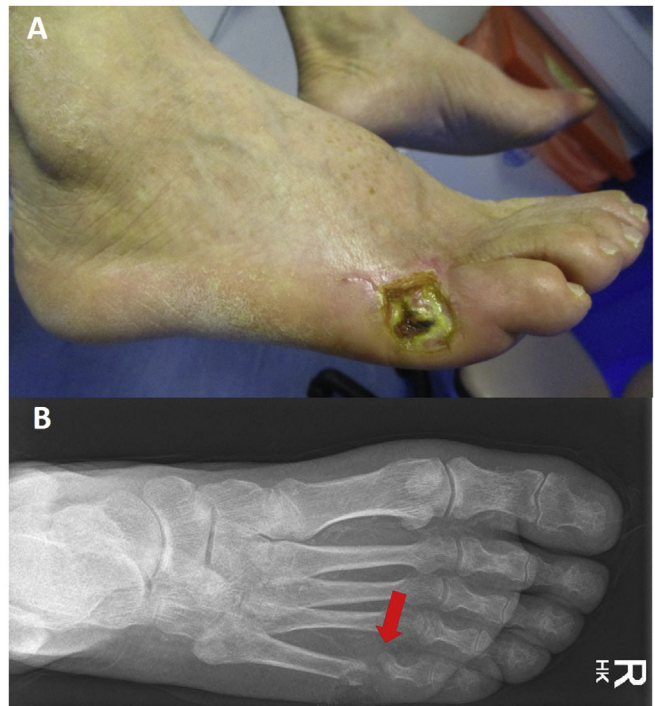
Diabetic foot ulceration. (a) Diabetic foot ulcer on the lateral aspect of the right foot. (b) Radiograph of the same ulcer demonstrating osteomyelitis of the 5th metatarsal head (red arrow). Note is also made of calcified pedal vessels.
